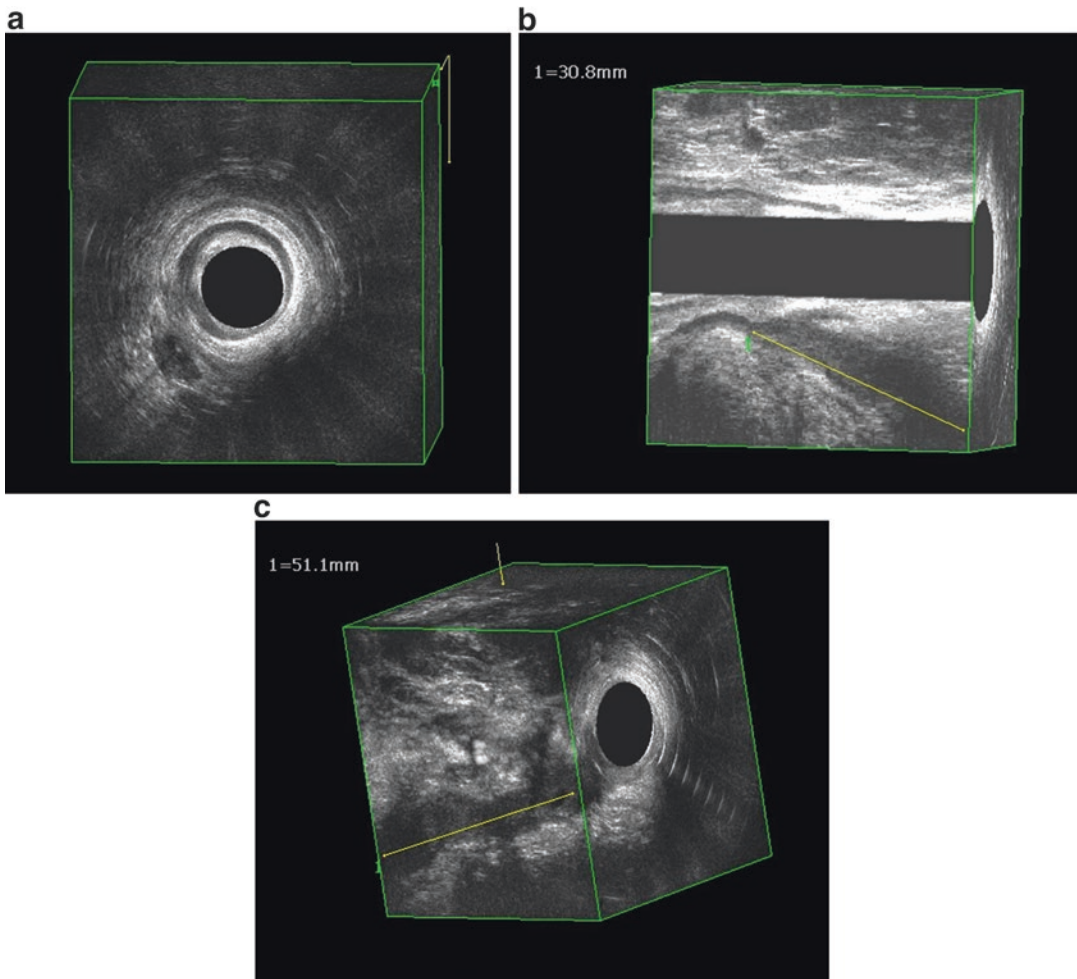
3D endoanal ultrasound with BK 2052 probe. (a) A hypoechoic tract is traversing posteriorly the external anal sphincter. (b, c) Reconstructions in the sagittal plane confirm a posterior transsphincteric fistula
